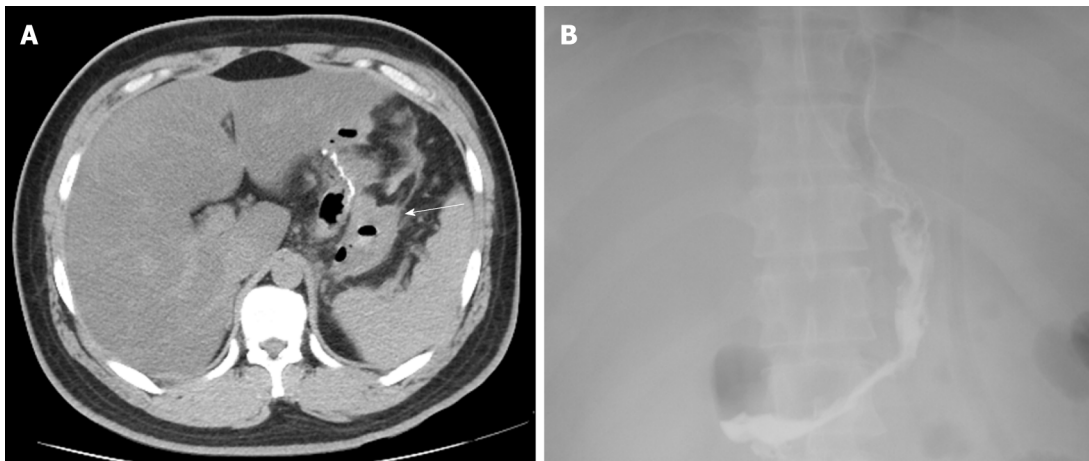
Imaging findings in Case 2. A: A blood clot and peritoneal cavity free air were found; B: No gastric leakage was detected by upper gastrointestinal radiography.
